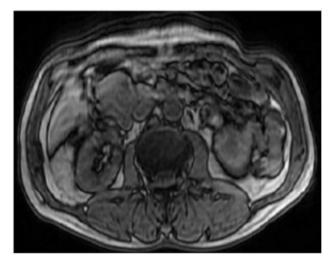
Axial T1-weighted image demonstrating soft tissue mass of slightly low signal intensity at the head of pancreas.
